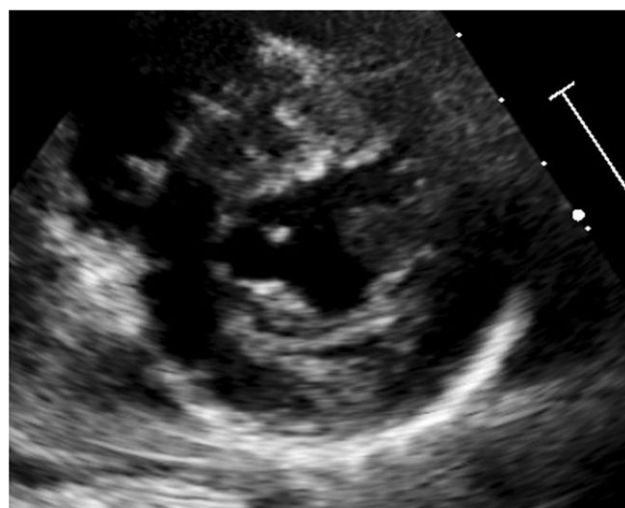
Parasternal short-axis mid-cavity view allows for assessment of end-diastolic posterior and septal wall thicknesses and relative end-diastolic dimension.
